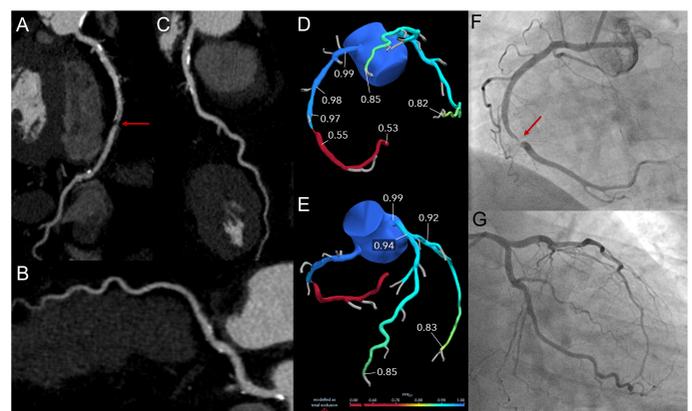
A 60-year-old man with dyslipidaemia and a family history of CAD presented with exertional chest pain, and CCT was performed. (A) Evidence of severe luminal narrowing in the right coronary artery (RCA) (red arrow), and (B) mild stenosis in the left main (LM), (C) circumflex (Cx), and (D) proximal left anterior descending (LAD). FFR_{CT} demonstrated (E) a remarkable FFR_{CT} value at the level of RCA stenosis, (F) while showing normal values in LAD and Cx; (G) invasive coronary angiography confirmed critical stenosis in RCA (red arrow) and (H) mild stenoses in LM, Cx, and LAD. This image was provided by Professor Gianluca Pontone and was also used in my review article as referenced in reference 2.
